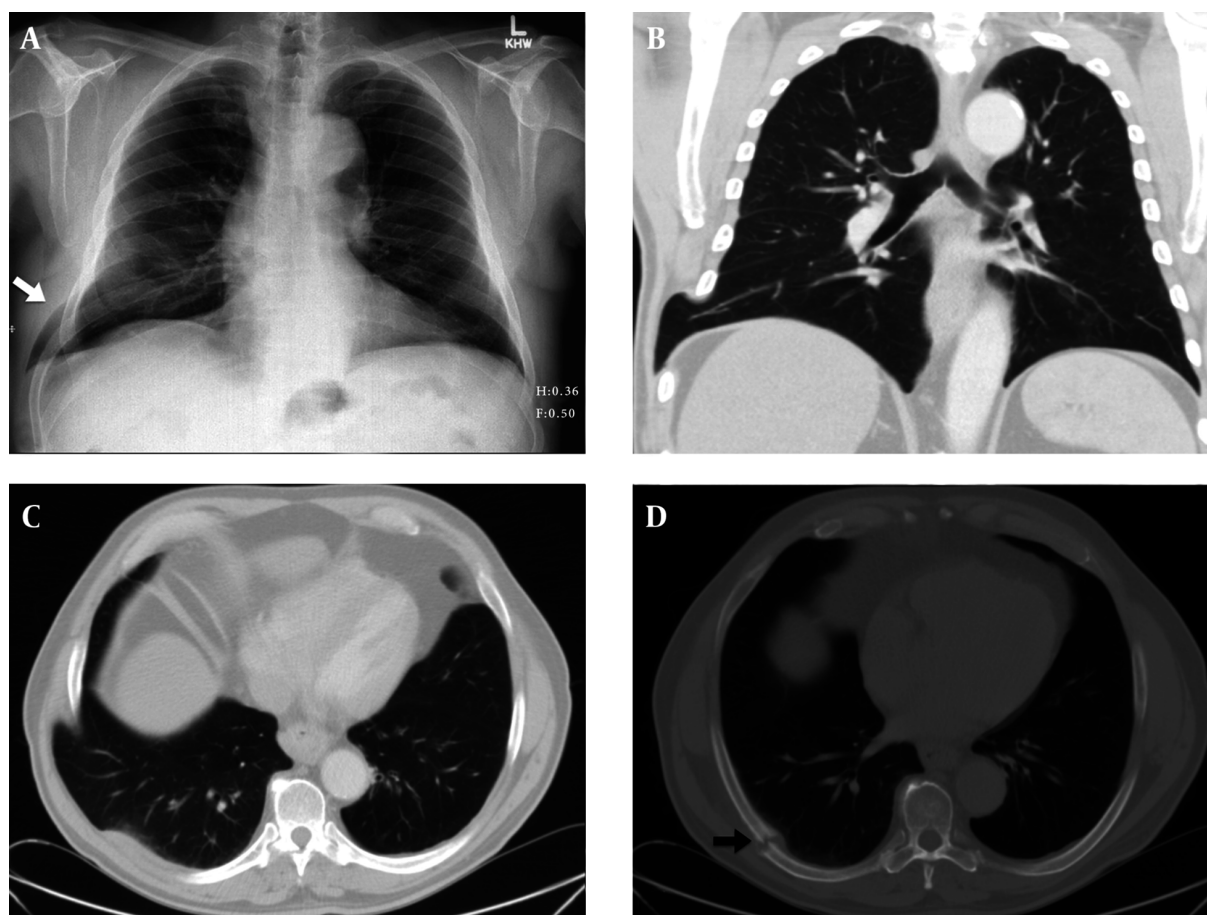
Admission PA chest radiograph; A, shows the right lung field extending outside the chest wall between the right 8th and 9th ribs laterally (white arrow). Coronal reformat image from subsequent contrast enhanced CT of the chest; B, (lung window) displays the traumatic herniation of the right lower lobe through a muscular defect in the 8th intercostal space to advantage. Axial images from the same CT at the level of the 8th intercostal space; C, (lung window) and a few slices higher; D, (bone window) again show the herniated portion of the right lower lobe and the subacute right 8th rib fracture associated with this injury (black arrow). Notice the widening of the 8th intercostal space on the radiograph and CT images relative to the left.
